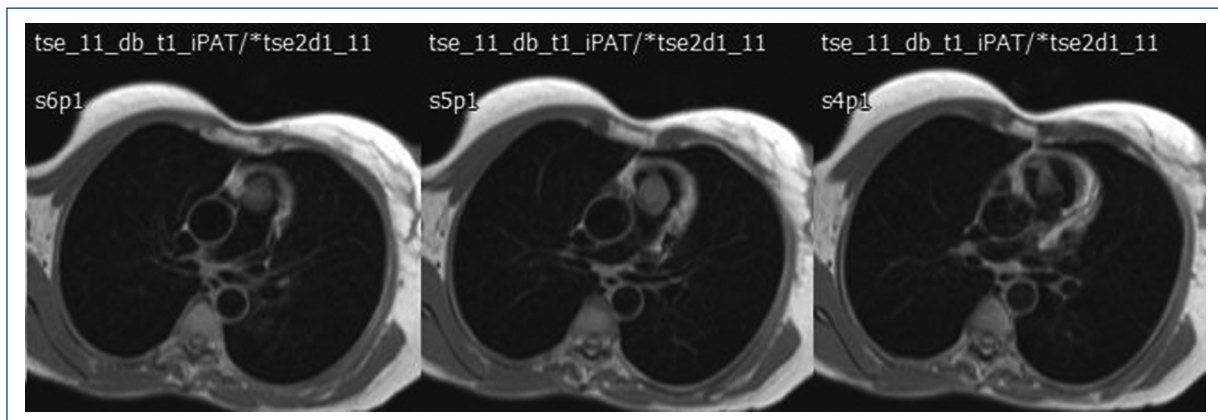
Cardiac magnetic resonance. CMR shows a well-defined, pedunculated mass, arising from de RVOT, occupying 80% of the RVOT (36 × 32 × 20 mm), isointense on T1-weighted images. RVOT: right ventricular outflow tract.
